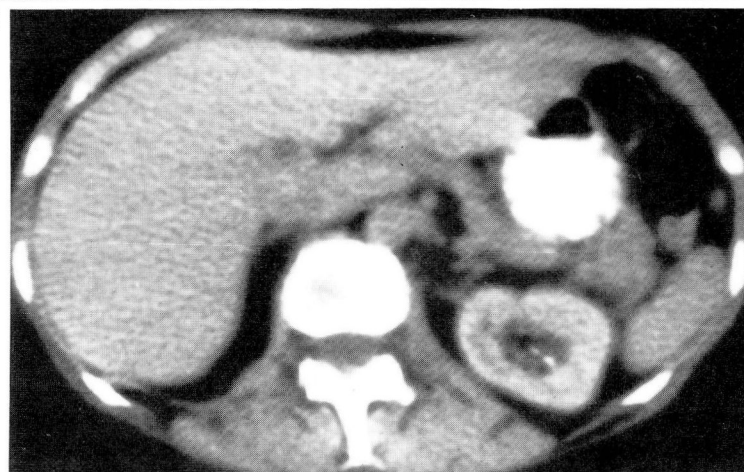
Serial CT scans of the same section of the liver.
